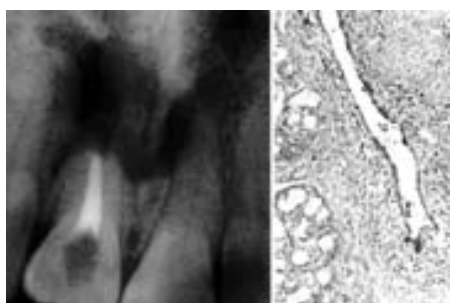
A persistent periapical radiolucency that upon biopsy (right) was found to be a nasopalatine duct cyst. Lobules of anterior palatal salivary gland can be seen to the left of the cystic lesion.
